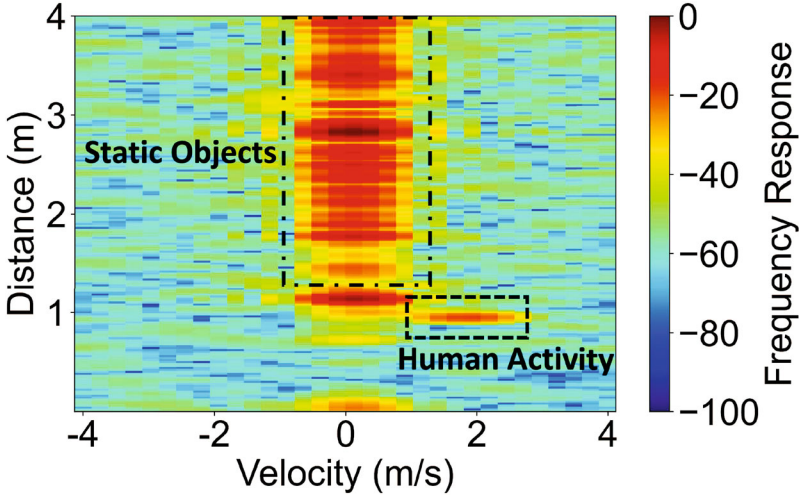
Doppler-Range Heatmap when one user is eating using a fork
